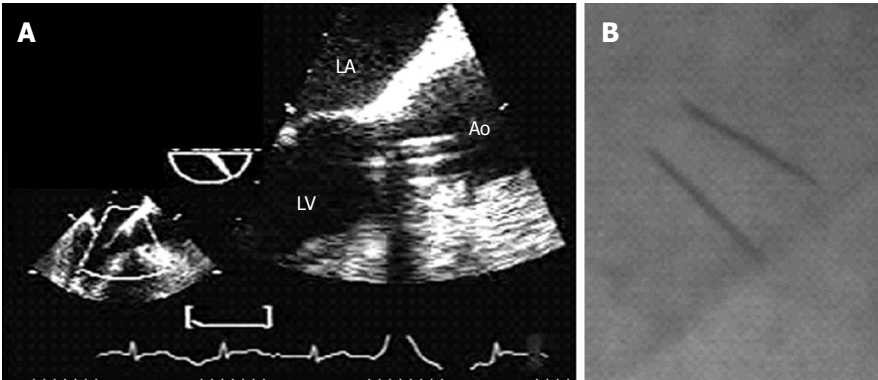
Transesophageal echo and fluoroscopy. A: Transesophageal Echo: 3-chamber view at 129°, with zoom in the LV outflow tract, showing the prosthetic valve with its parallel discs; B: Fluoroscopy showing the almost parallel tilting discs. Both exams confirm an adequate prosthetic valve opening. LA: Left atrium; LV: Left ventricle; Ao: Aorta.
